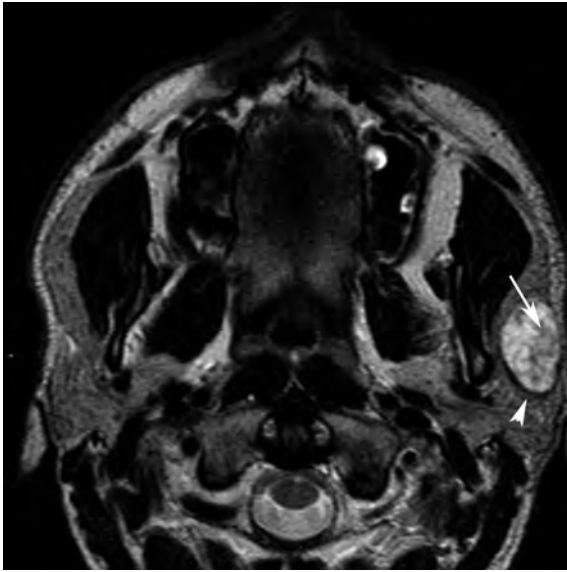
Pleomorphic adenoma of the left parotid gland with a high T2-weighted signal intensity and small heterogeneous areas of lower signal intensity, related to myxoid degeneration (arrow). The capsule is well identified (arrowhead)
